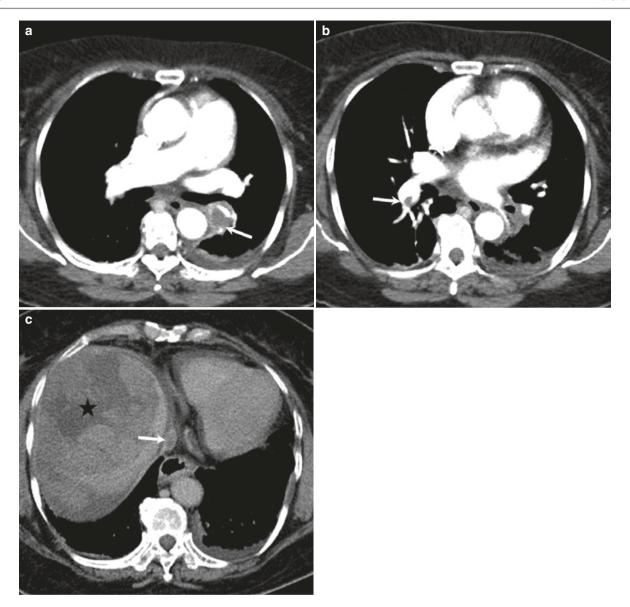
Tumor embolism in a patient with hepatocellular carcinoma. (a, b) Axial CTPA images show thrombus in bilateral lower lobe pulmonary arteries (arrows). (c) Axial CT image in venous phase shows a
